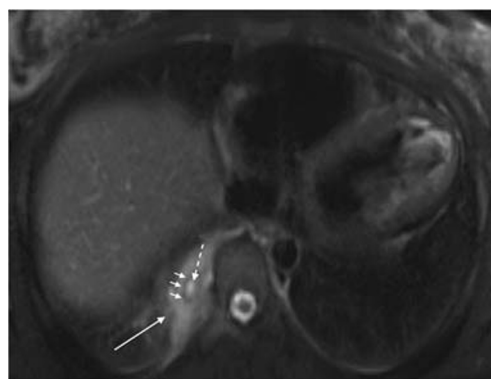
Young female with history of intravenous drug abuse presenting for pulmonary embolism evaluation. MR axial fat-saturated T2-weighted image shows focal peripheral consolidation (white arrow) in the medial right lower lobe with central area of high T2 signal (dashed white arrow) surrounded by a hypointense rim (multiple short white arrows). Findings are consistent with consolidation with abscess formation, indicating focal abscess formation in the consolidation
